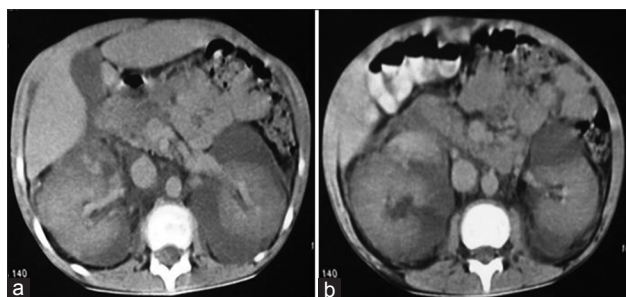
Renal lymphangiectasia. Non-contrast computed tomography abdomen axial images show perinephric fluid collection bilaterally, with hyperdense focus of haemorrhage in the collection anterior to midpole of right kidney.
